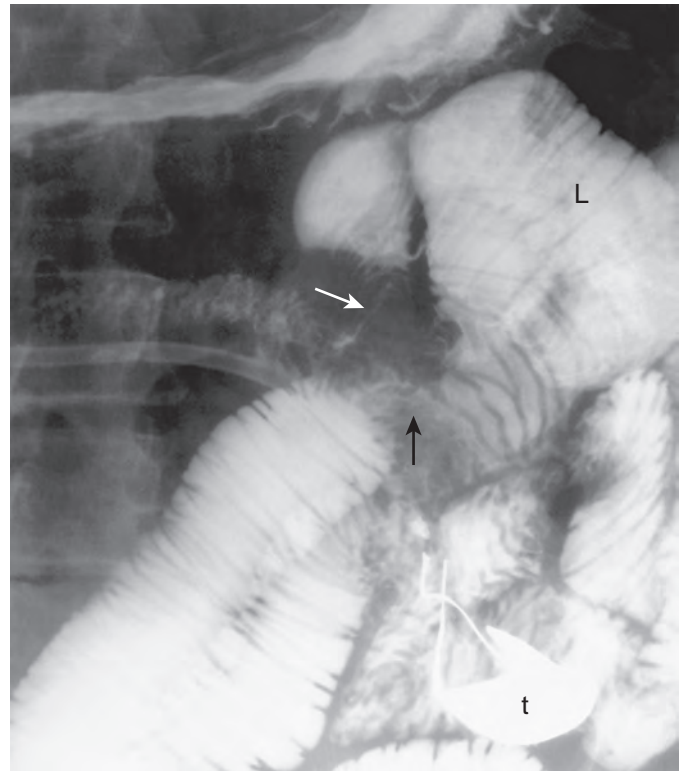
Left paraduodenal hernia. This coned-down image from overhead radiograph on enteroclysis performed via a Kantor tube (t) shows a cluster of jejunal loops (L) in the left upper quadrant. These loops are extrinsically compressed (*arrows*) at the entry site to the fossa of Landzert. (Courtesy Hans Herlinger, MD.)
